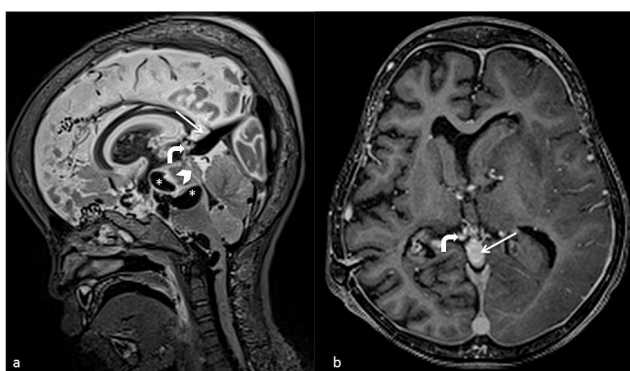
MRI of the brain in sagittal T2WI and contrast-enhanced T1 MPRAGE demonstrate multiple serpiginous flow voids (star and bent arrow) representing dilated venous channels.
